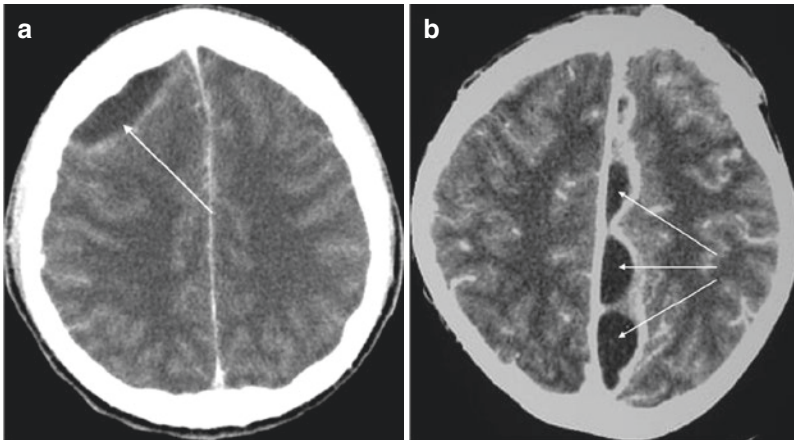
(a) CT scan post contrast imaging in patient with subdural empyema. In this image, there is a large right frontal collection that is slightly hypodense and has some contrast enhancement at its periphery, most suggestive of a subdural empyema (solid arrow). In this example, the subdural empyema has taken on a lentiform appearance and without closer inspection, may be mistaken for an epidural abscess. Note the associated displacement of the brain parenchyma. (b). CT post contrast imaging in patient with interhemispheric subdural empyema. In this image, we can appreciate the significant hypodense collection in the interhemispheric space (arrows) with avid contrast enhancement at the periphery. The collection is able to extend and fill out the interhemispheric space and is most in keeping with a subdural empyema
